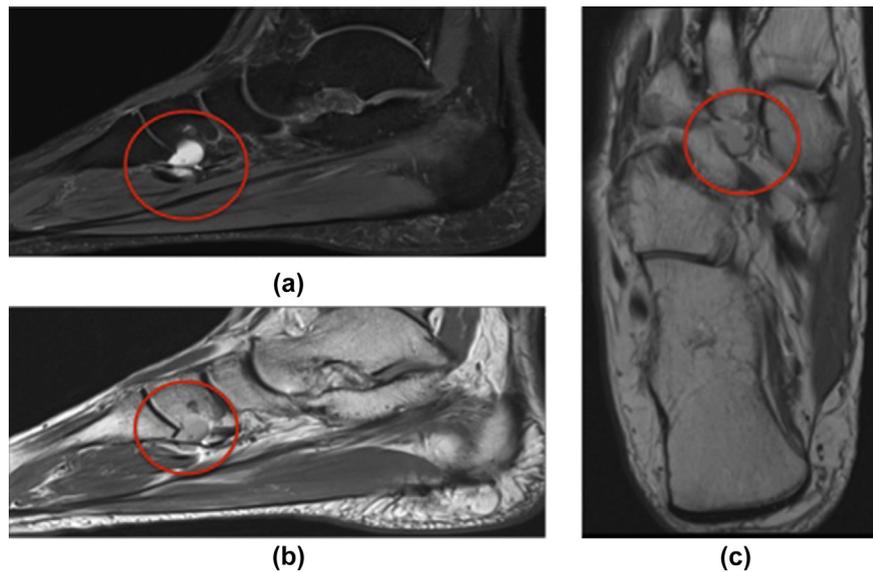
(a) PD FS sagittal, (b) PD sagittal, (c) PD axial MRI images show a small well-defined unilocular cystic lesion in relation to the knot of the Henry, with volar protrusion. It is of cystic signal on FS imaging and intermediate signal on T1 sequences consistent with a ganglion with internal mucinous material.
